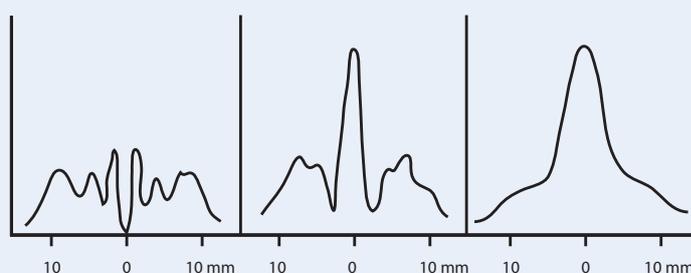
Cross-section of the ultrasound bundle
